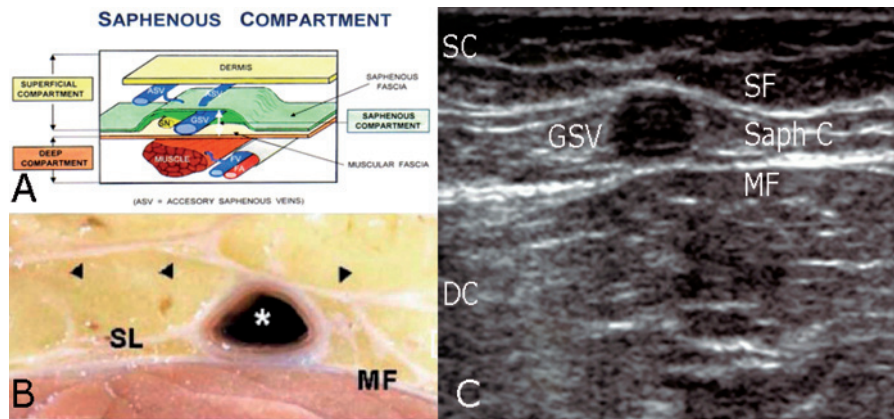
A. The saphenous compartment (SaphC) is bound superficially by the saphenous fascia (SF) and deeply by the muscular fascia (MF). It contains the saphenous veins (SV) and the saphenous nerve (SN). The accessory saphenous veins (ASV) lie external to this compartment, close to the dermis (D). SC, superficial compartment; DC, deep compartment. (Adapted from Reference 19.) B. Axial section from a cadaveric limb. The Great Saphenous vein enclosed in the saphenous compartment is clearly visualized. MF, muscular fascia; SL saphenous ligament. (Adapted from Reference 25.) C. Sonography of the Great Saphenous vein at mid thigh. The hyperechoic saphenous fascia (SF) and muscular fascia (MF) define the saphenous compartment in which the Great Saphenous vein courses.
